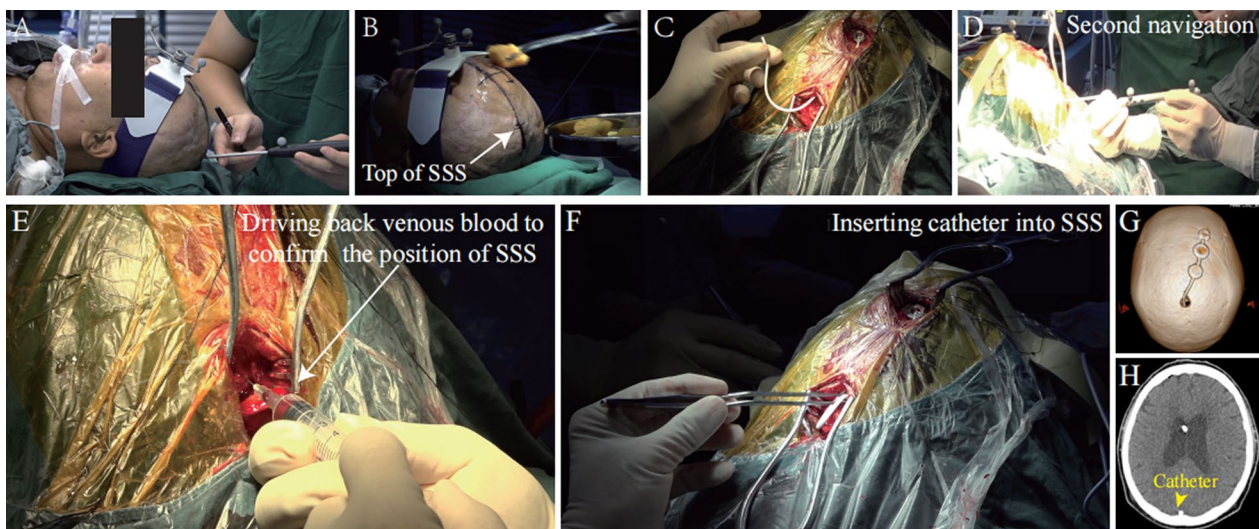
Procedures for VSS shunt. Surgical design: With the application of a computer-assisted stereotactic neurosurgery system (a), two incisions were made at the routine frontal puncture point and the top of the SSS (b). The ventricular puncture was completed, and the catheter was introduced forward through the subcutaneous tunnel (c). The position of the SSS was confirmed with the navigation system before the SSS was cut (d). A syringe was used to carefully draw back venous blood. The precise location of the SSS was confirmed by the blood in a syringe (e). The prepared catheter was slowly inserted into the SSS (f). The exact implantation of a fixed VSS shunt system was checked postoperatively via 3D reconstructed CT scans (g, h)
